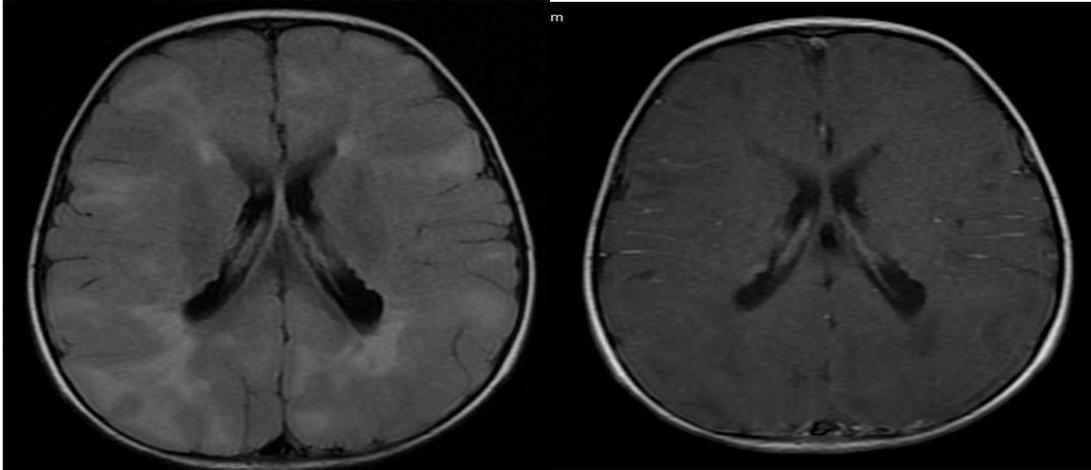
A, axial T2 FLAIR and B, axial T1 post-gadolinium, showing multiple images compatible with cortical tubercles distributed over the cerebral hemispheres and subependymal nodules (arrows) in a 1-year and 4-month-old female patient.
